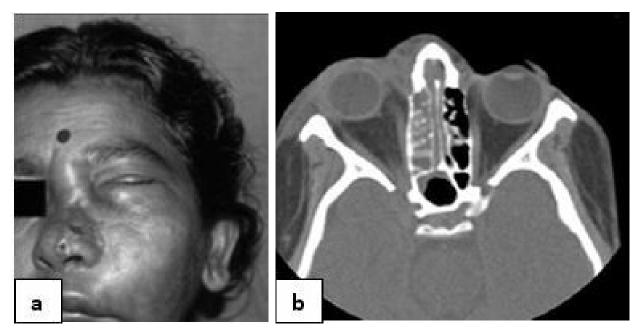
(a): Clinical picture of mucormycosis: swelling over face, eyelid and nose with dystopia (left side); (b): CT scan axial section of the orbits shows opacification of the right paranasal sinus and medial orbital involvement.
